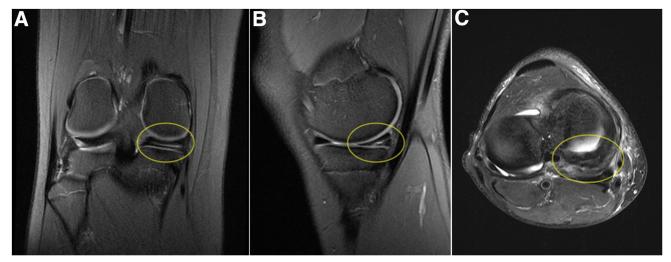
(A) Coronal, (B) sagittal, and (C) axial MRI views of a right knee showing a horizontal tear involving the posterior horn of the medial meniscus from its central avascular part to its wall. (MRI, magnetic resonance imaging.)
